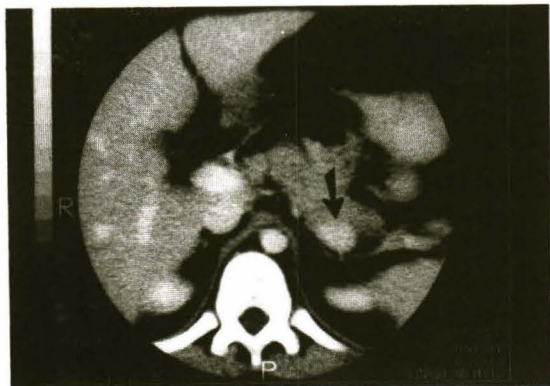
Insulinoma. Axial CT scan with 5 mm thick sections through the pancreas after intravenous contrast enhancement, reveals intense enhancing mass (arrow) at posterior aspect of tail of pancreas.
